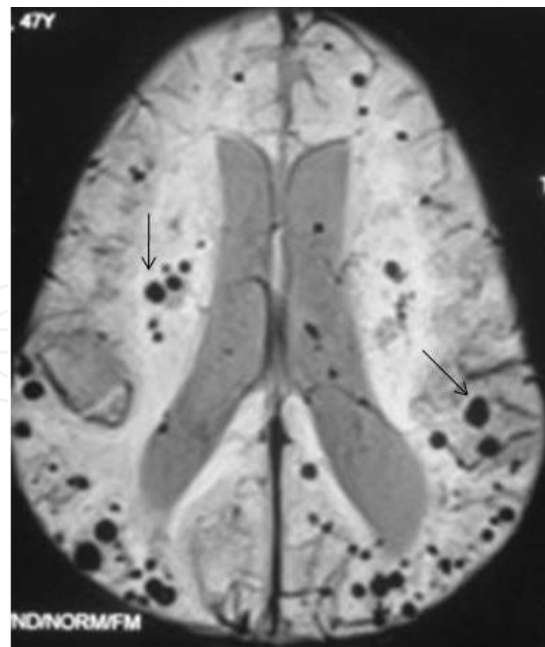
T2*-weighted gradient-echo MR image of a 62-year-old male patient shows diffuse and small multifocal hemosiderin deposits (chronic microhemorrhages) in corticosubcortical location of both the cerebral hemispheres, seen as signal void areas (blooming) (arrows).
